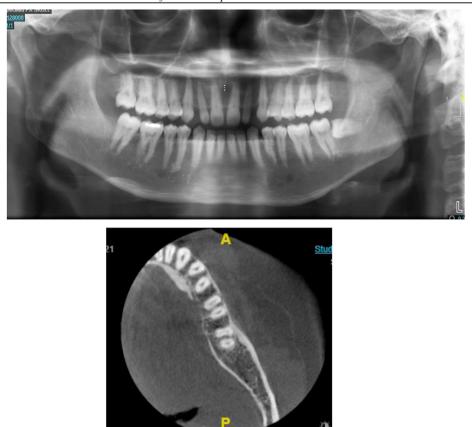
Panoramic imaging did not reveal any bony abnormalities, however cone beam tomography (axial view) revealed lingual bone discontinuity consistent with bone resorption.
